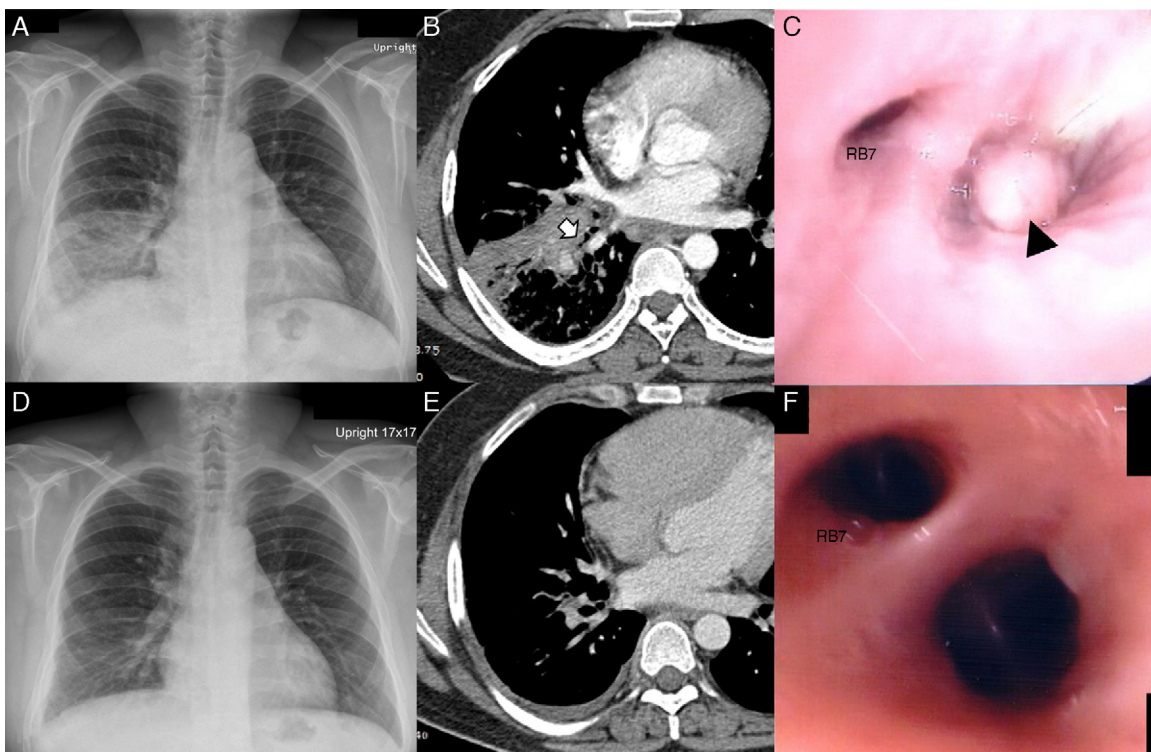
(A) Chest X-ray on initial presentation, in which a mottled ground glass opacity and consolidation at the level of the right lower lobe can be seen. (B) Chest computed axial tomography (CT) image in a mediastinal window setting, showing an area of consolidation at the level of the right lower lobe, with an endobronchial lesion obstructing the basal segmented bronchi (arrow). (C) Bronchoscopy revealed a whitish endobronchial mass (arrow) at the opening of the basal anterior, lateral and posterior segmented bronchi of the right lower lobe. The follow-up chest X-ray (D) and chest CT (E) showed improvement of this lesion. The basal segmented bronchi in the right lower lobe were restored and identified on the chest CT (E) and in the bronchoscopy image (F). RB7: medial basal segmented bronchus of the right lower lobe.
